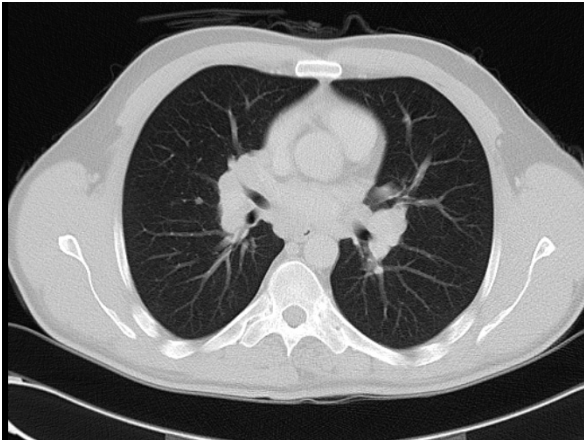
The paranchymal nodule seen at the right lung in the thoracic computed tomography
